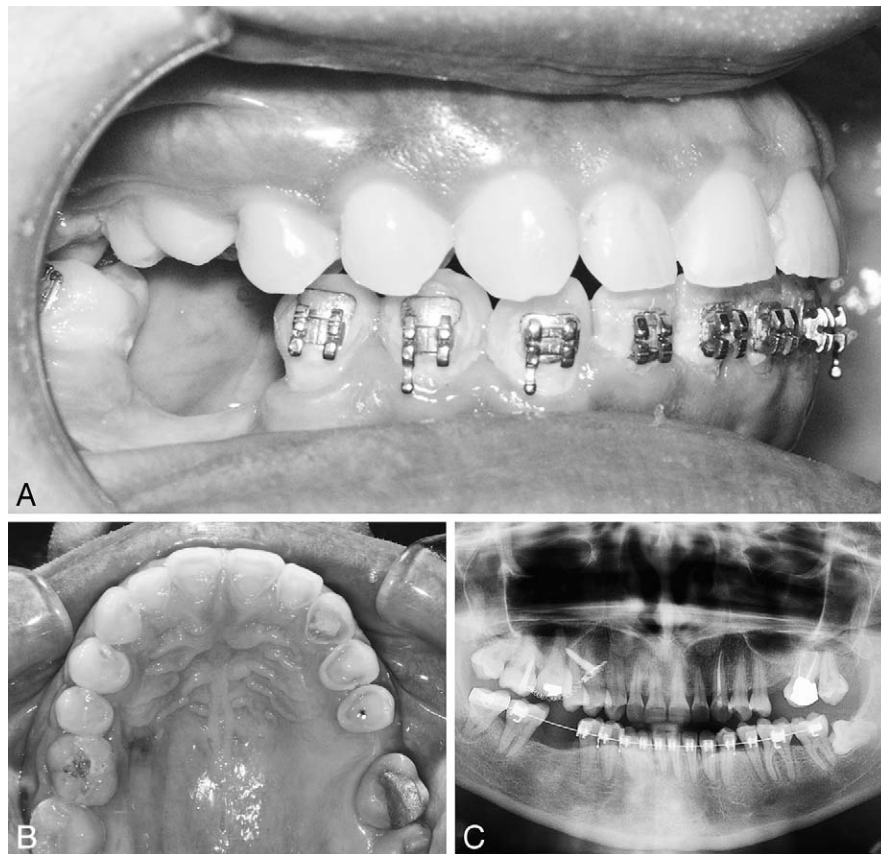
(A) Successful intrusion after 6 months without partial fixed appliances or prosthodontic reduction. Photo taken on the day of miniscrew removal. (B) (Right) Palatal crown tipping due to intrusion mechanics. Photo taken on the day of miniscrew removal. (C) Panoramic radiograph taken on the day of miniscrew removal. Maxillary right first molar intruded 1 to 2 mm above the occlusal plane.
